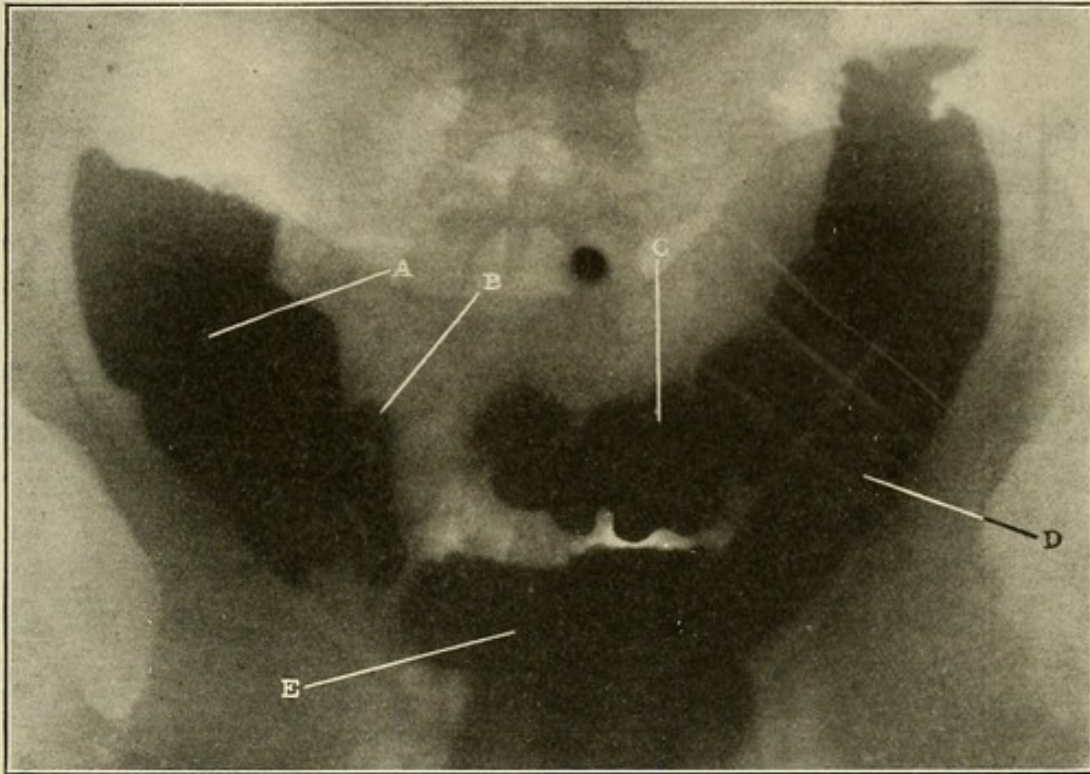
Lane's kink and coloaptosis. (*Made in the X-ray laboratory of Dr. Anthony Bassler, New York City.*)
